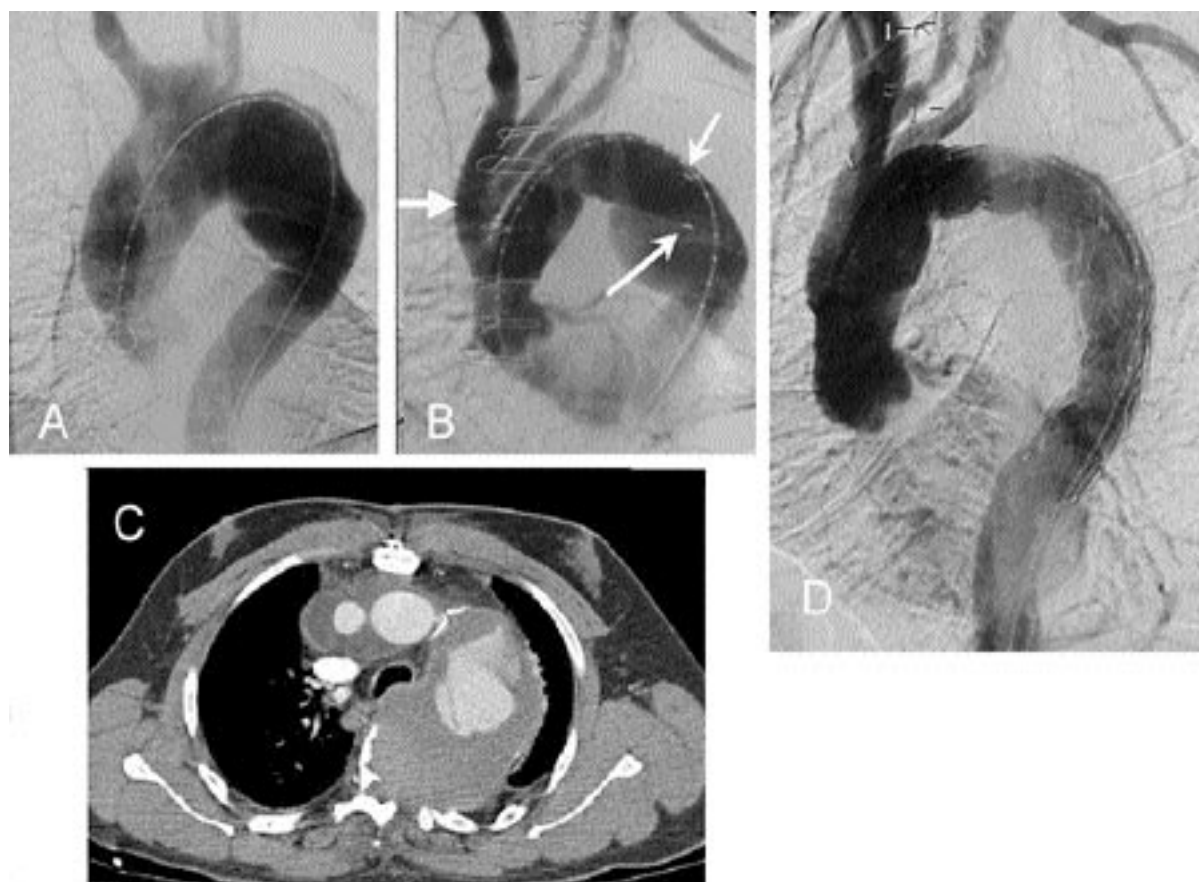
(A) Angiogram demonstrating aortic arch aneurysm. (B) Aortic arch angiogram following elephant trunk reconstruction. The proximal graft begins at the aortic root. Arrow at left points to bifurcated graft originating from main aortic graft to revascularize the arch branches. Long arrows identify markers placed on distal end of graft within the aneurysmal proximal descending thoracic aorta. (C) Chest CT demonstrating aneurysmal descending thoracic aorta. (D) Aortic angiogram following stent-graft exclusion of a descending thoracic aortic aneurysm. Proximal stent-graft positioned within the previous elephant trunk graft.
